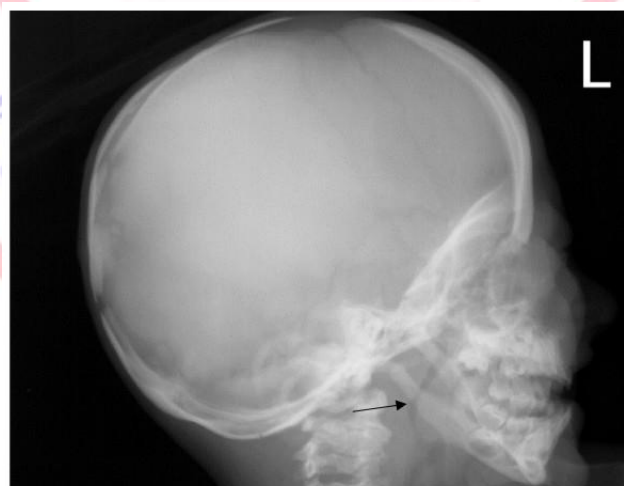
Lateral skull radiograph note increased thickness of vault.
